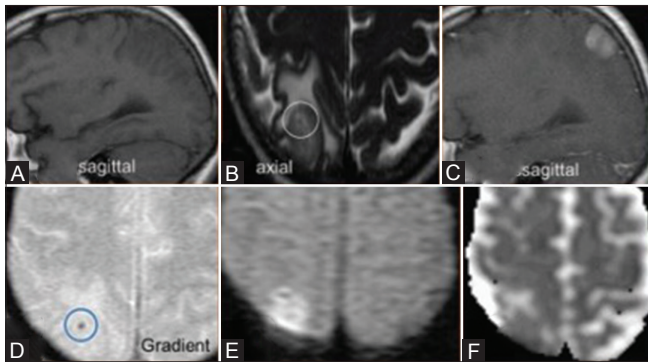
(A-F): History – A 28-year-old immunocompetent female presented with severe headache for 1 month. MRI showed a right parietal cortical lesion hypointense on T1 W (A) and T2 W (B) images with homogenous enhancement on post-contrast T1 image (C). There was a single speck of blooming (circle) within the lesion on gradient image (D) which could represent calcification/hemorrhage. There was also restricted diffusion within the lesion on diffusion weighted and ADC images (E and F)
